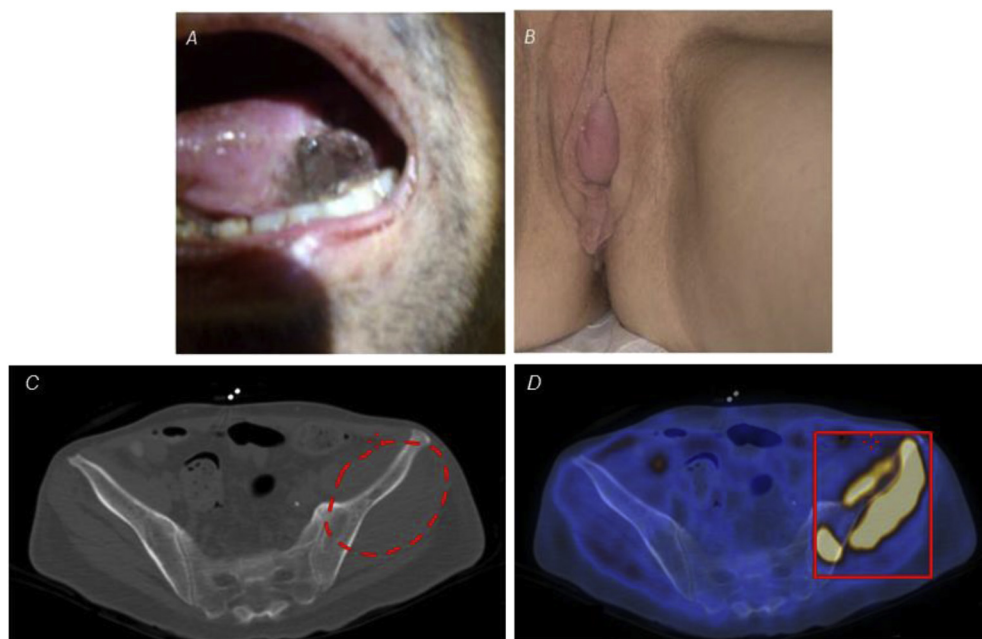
Clinical and radiographic appearance of chloroma in the oral cavity (A) and vulva (B). An axial CT scan (C) and positron emission tomography scan (dashed line) (D) show a chloroma in the left hemipelvis (rectangle). *Abbreviation:* CT = computed tomography
